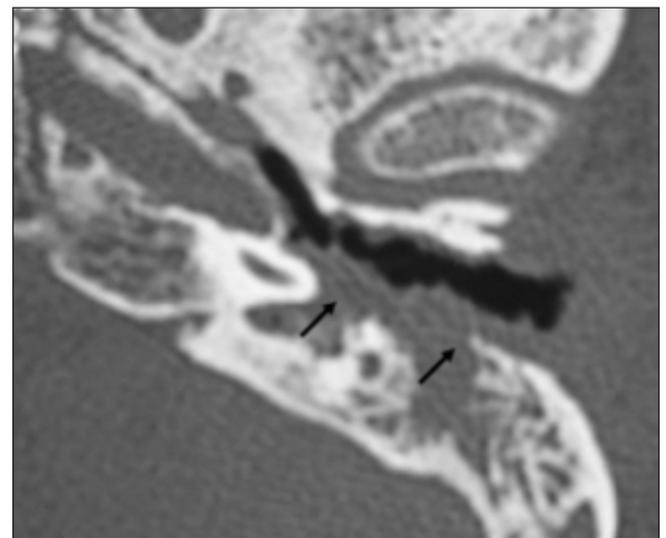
Axial and coronal views of high resolution CT scan of the petrous temporal bone: A soft tissue filling the entire duct associated with erosion of the posterior and inferior walls of the canal and of the lateral attic wall.
